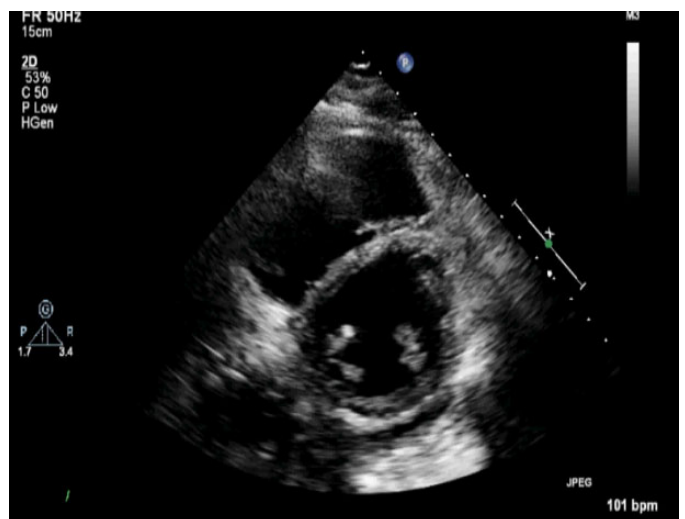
Post pericardiocentesis biventricular dilatation (Parasternal short axis view).
